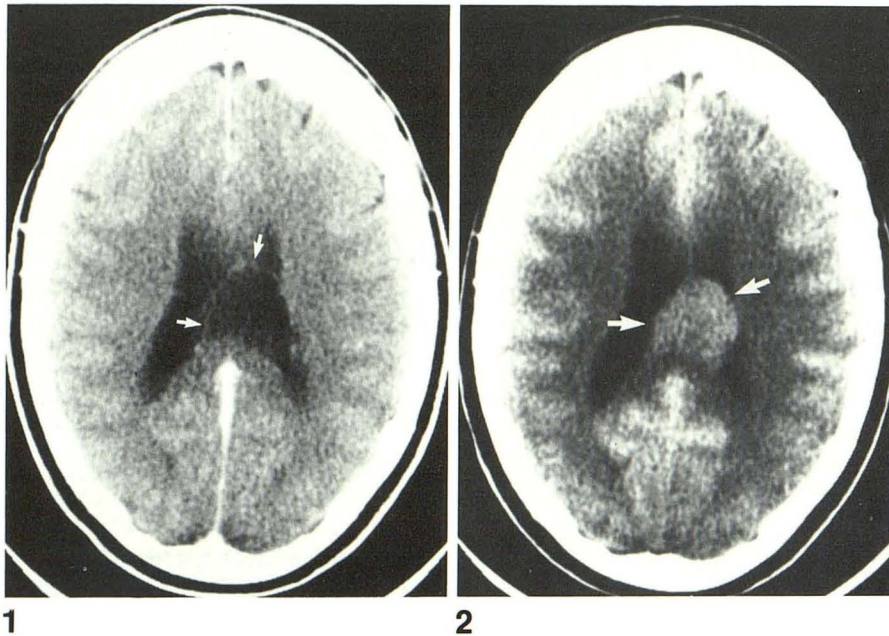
CT scan shows cyst in velum interpositum (arrows) at level of lateral ventricle bodies.
